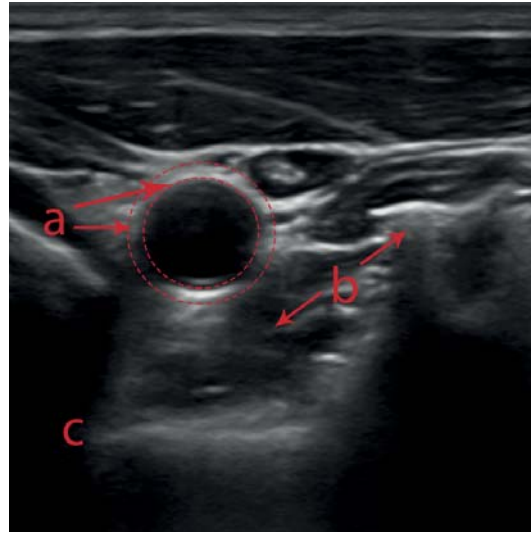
Ultrasound image appearance: a) differences between horizontal and vertical gradients, where gradients perpendicular to the ultrasound beam are stronger, b) attenuation/shadowing artifacts by strong reflectors or vertical edges, resulting in beam attenuation, c) characteristic attenuation in ultrasound images for deep regions. The region marked by the dashed lines shows the bright outer border ring around the vessel lumen.
